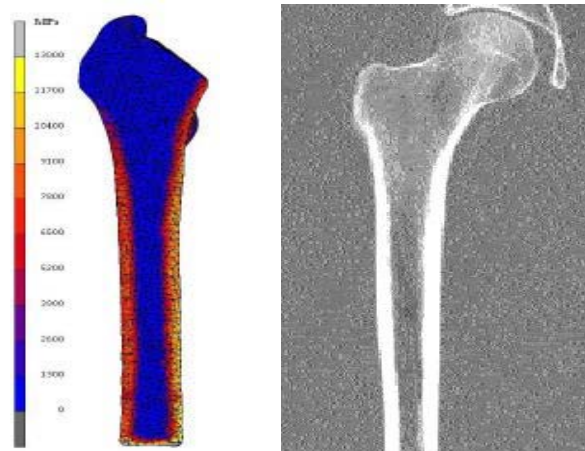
The contour plots of stiffness of femoral bone using the bone properties algorithm (left) and the corresponding image from the VHP CT dataset
